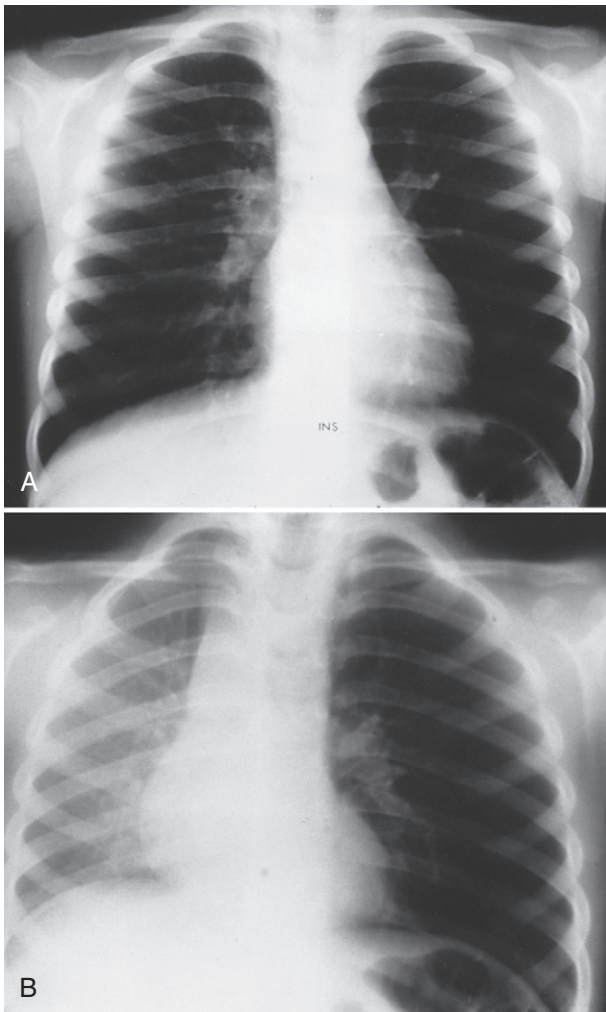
A, Inspiratory chest radiograph with foreign body present in left mainstem bronchus. The left lung is slightly hyperinflated but could be considered normal. B, Expiratory chest radiograph with foreign body present in left mainstem bronchus. The left lung is clearly hyperinflated because of air trapping by the foreign body. (A and B, Courtesy Eric Effmann, MD.)
